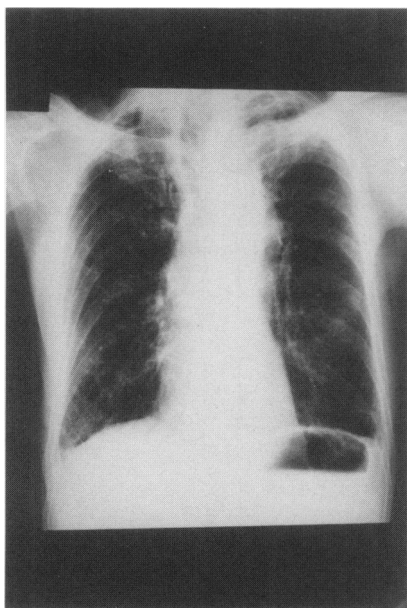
Preoperation chest X-ray.
